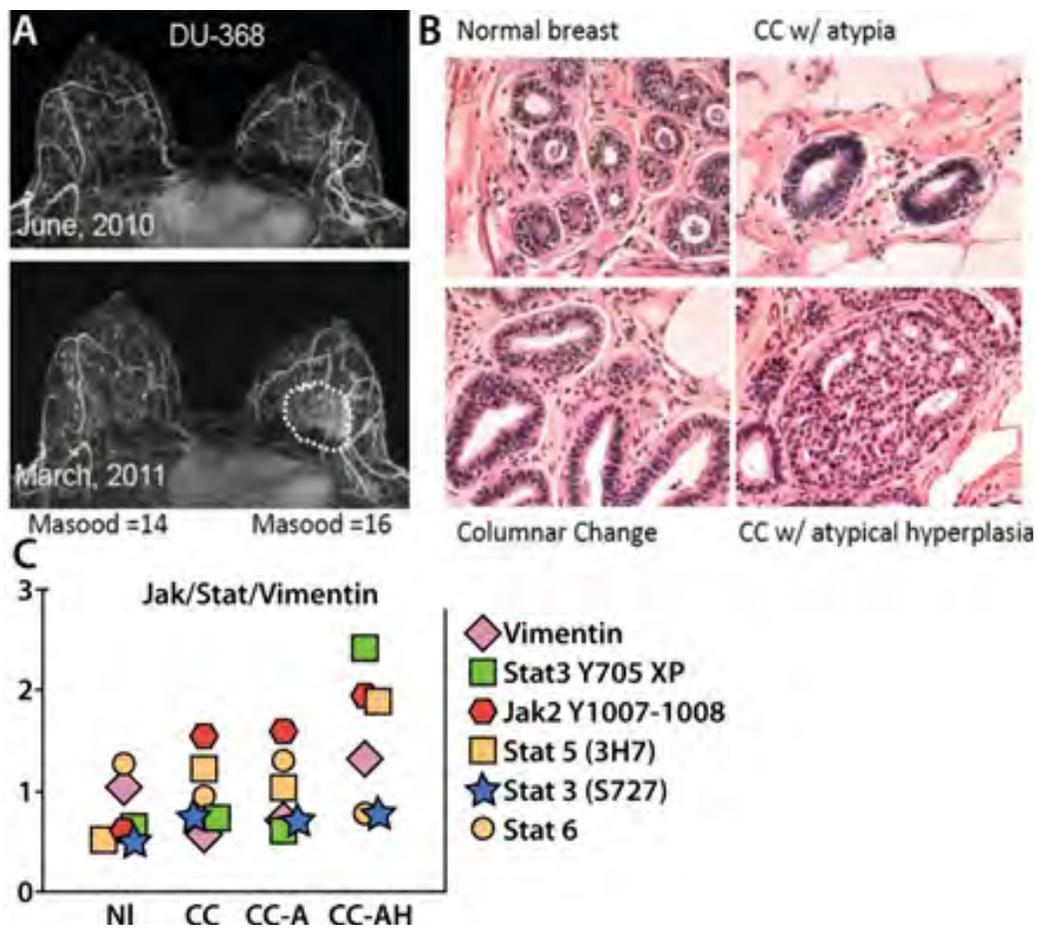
Temporal and spatial mapping of phospho-protein activation during breast cancer initiation in DU-368. More than 100 cores were obtained per breast. DU-368 is a 38-year-old African American woman with four family members with premenopausal breast cancer. (A) Breast MRI progression. (B) Early precancerous changes, normal (NL), columnar change (CC), CC with atypia (CC-A), CC-with atypical hyperplasia (CC-AH). (C) Activation of phospho-protein signaling is first observed in CC-AH.
